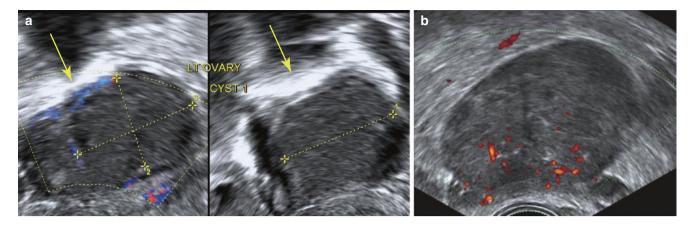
Differentiation between cystic and solid masses. (a) Cystic mass with turbid contents showing acoustic enhancement (*arrows*) and no flow on Doppler within. (b) Solid mass showing flow within on Doppler and no acoustic enhancement
